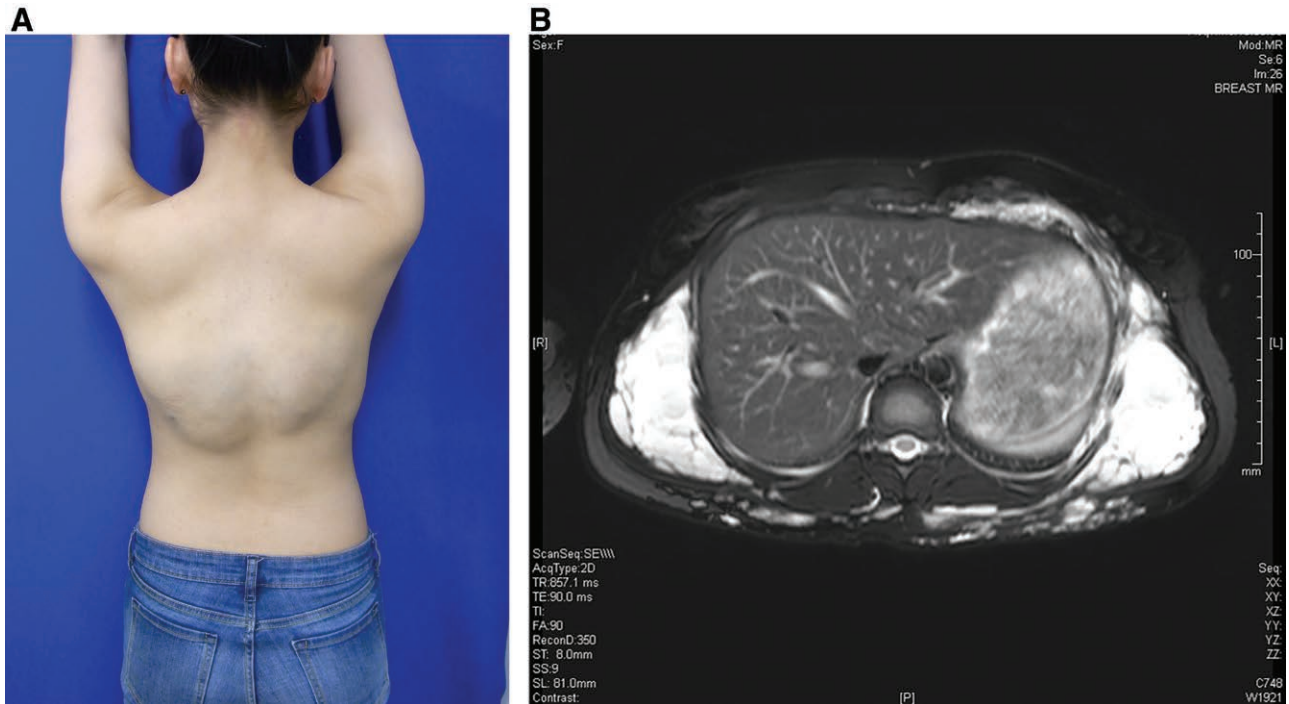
Pre-treatment findings. A, Venous malformation from the dorsal area to the lateral chest, enlarging and blue in color. B, Preoperative MRI showing the lesion (arrowheads). It involves the dorsal and the lateral chest area.
